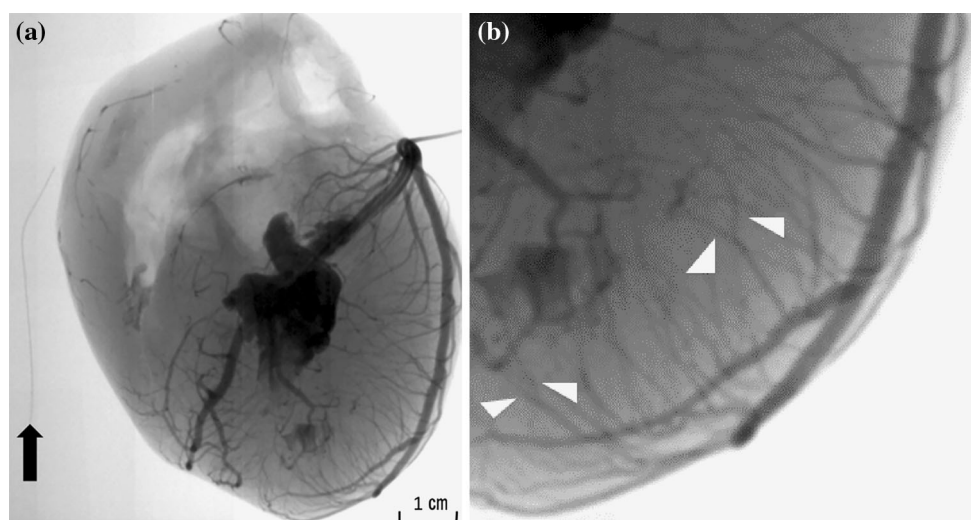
An excised heart irradiated by the conventional X-ray system. a The image was obtained by the conventional X-ray system set at 100 kV, 50 mA, and 100 ms of tube voltage, current, and exposure
